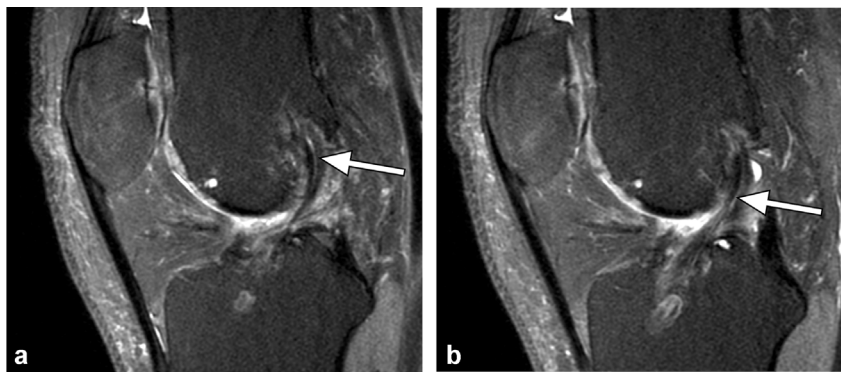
a and b: normal high signal intensity on fluid-sensitive sequences between the strands in an STGT reconstruction due to a small quantity of liquid (arrow). Sagittal fat-suppressed-PD-weighted MR image.
